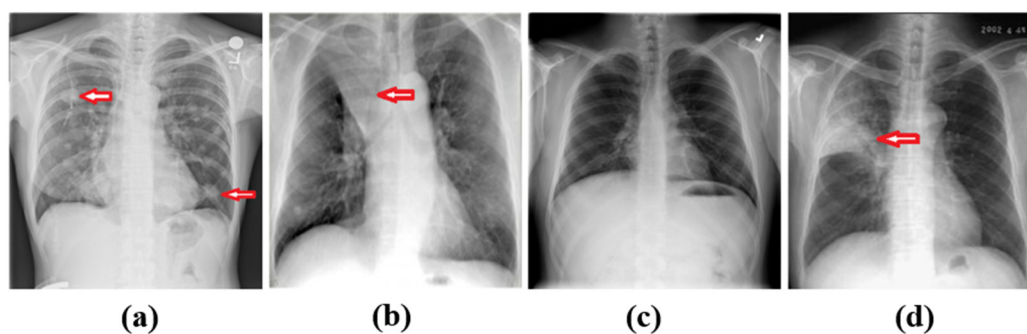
Randomly selected four types of chest X-ray images. (a) nodule, (b) atelectasis, (c) normal, (d) infection. Red arrow points to the disease area.
